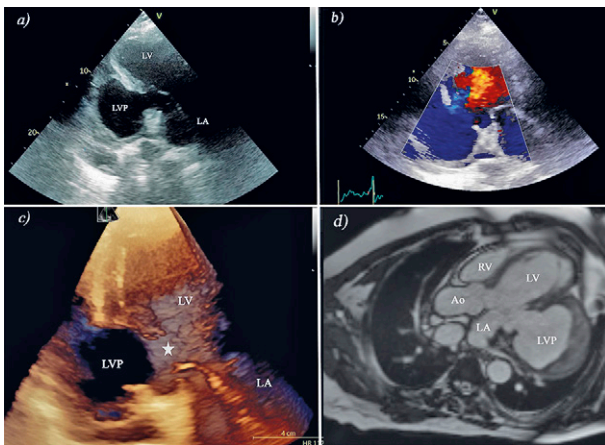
a) TTE showing giant LVP with a narrow neck and wide base in the inferior region of the LV; b) TTE with color Doppler through the cavity of the LVP; c) the 3D TTE demonstrating neck (asterisk) of the LVP and loss of continuity at the basal part of inferior wall; d) cardiac MRI scan of the partially thrombosed LVP with compression of the left atrium. LA - left atrium, LV - left ventricle, RV - right ventricle, LVP - left ventricle pseudoaneurysm, Ao - Aorta
